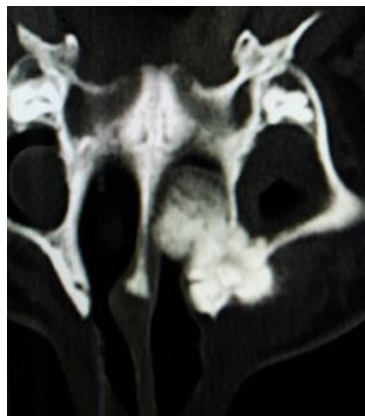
CT scan which shows infiltration of lateral wall of nasal cavity.
